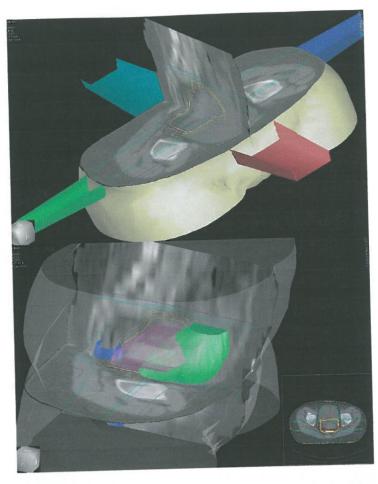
CT-based 3D plan for the boost treatment on a sagitally and axially opened and on a partially transparent 3D reconstruction.
